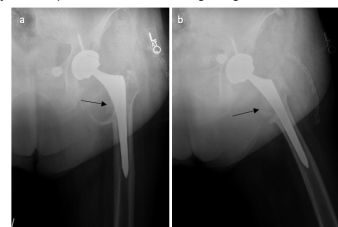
Post-operative AP (a) and Frog-leg (b) x-rays demonstrate appropriate placement of new revision ceramic ball and polyethylene hip liner with bone grafting material (indicated by arrows). A portion of the calcific rim that bordered the pseudotumor remains visible.
